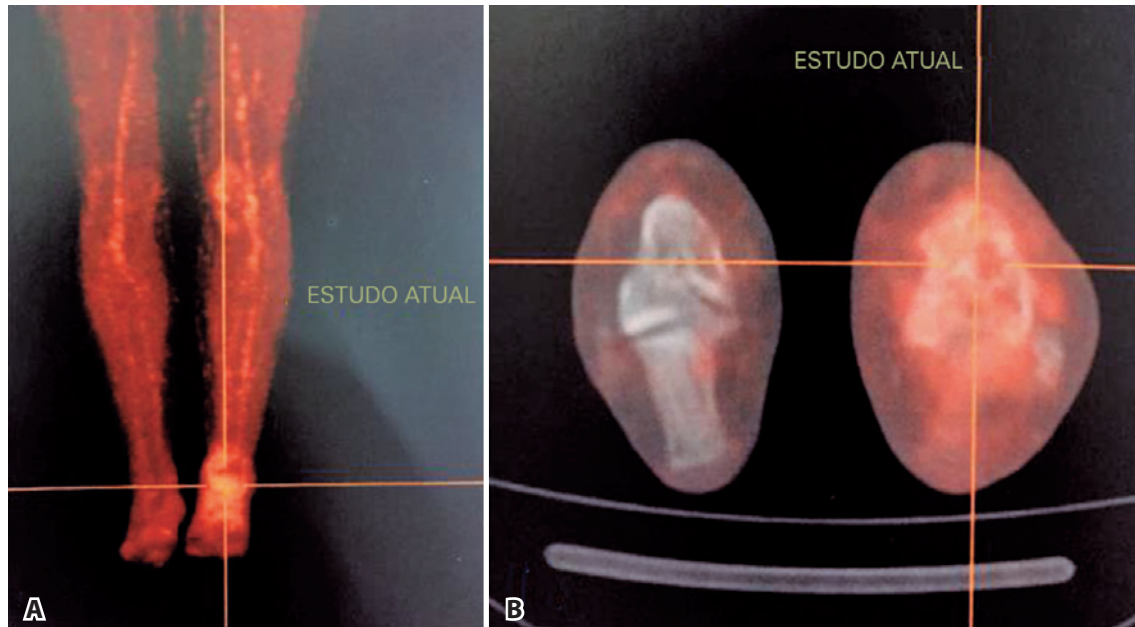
PET-CT images 5 months after the first exam. Note the reduction in the size and metabolic activity of the neoplastic process. A) coronal image of the lower limbs. B) axial image of the tarsal bones.
